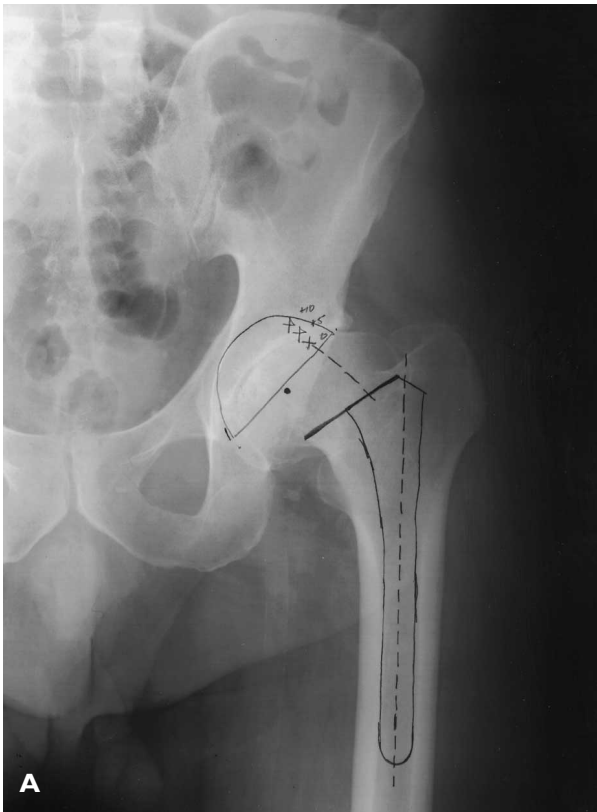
(A) Anteroposterior radiograph demonstrates templating of the acetabulum and femur. It is helpful to draw the desired socket position. The socket is drawn against the medial wall of the acetabulum (teardrop) and angled to transect the obturator foramen. Placing the inferior aspect of the cup level with the teardrop usually places the cup in proper abduction. An anteroposterior femur radiograph is helpful in sizing the femoral component and assessing proper varus and valgus alignment. Femoral offset is shown here, as well. (B) Lateral radiograph demonstrates templating of the acetabulum. Sizing of the socket is easy to determine with this view. The position of the socket relative to the ischium is helpful in determining proper anteversion.
